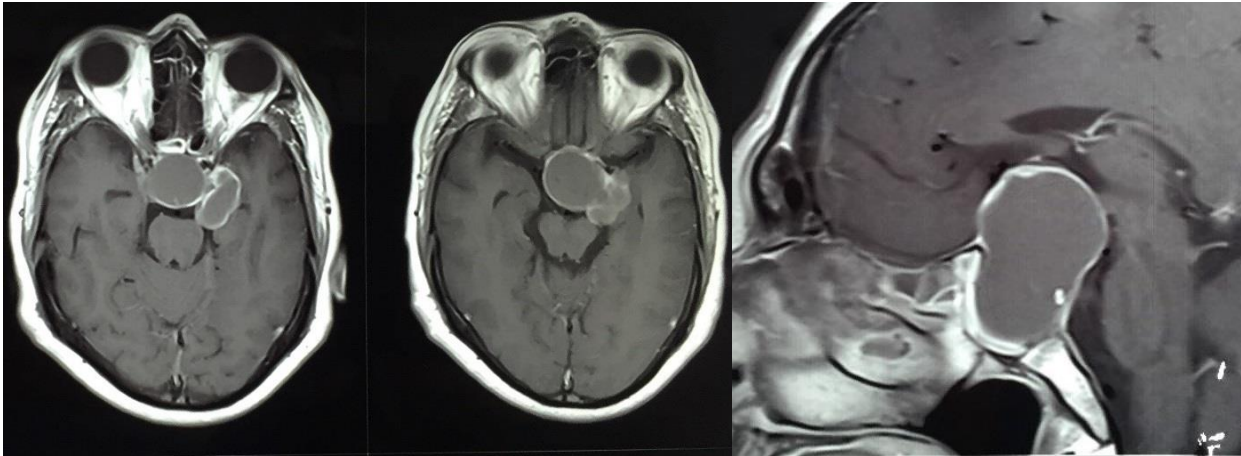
MRI images of the sellar region that show lesion with hypointense content in T1, with contrast uptake in capsule. Note the sphenoid sinus extension and left parasellar region.
